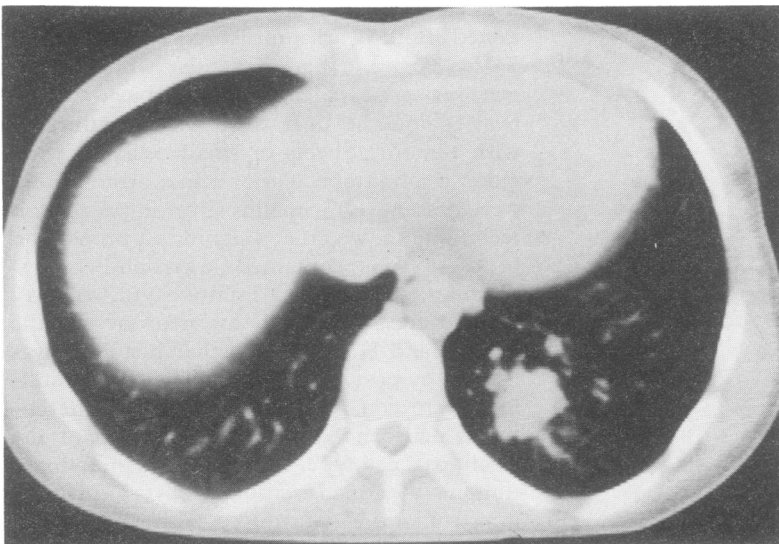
CT scan lung fields.
